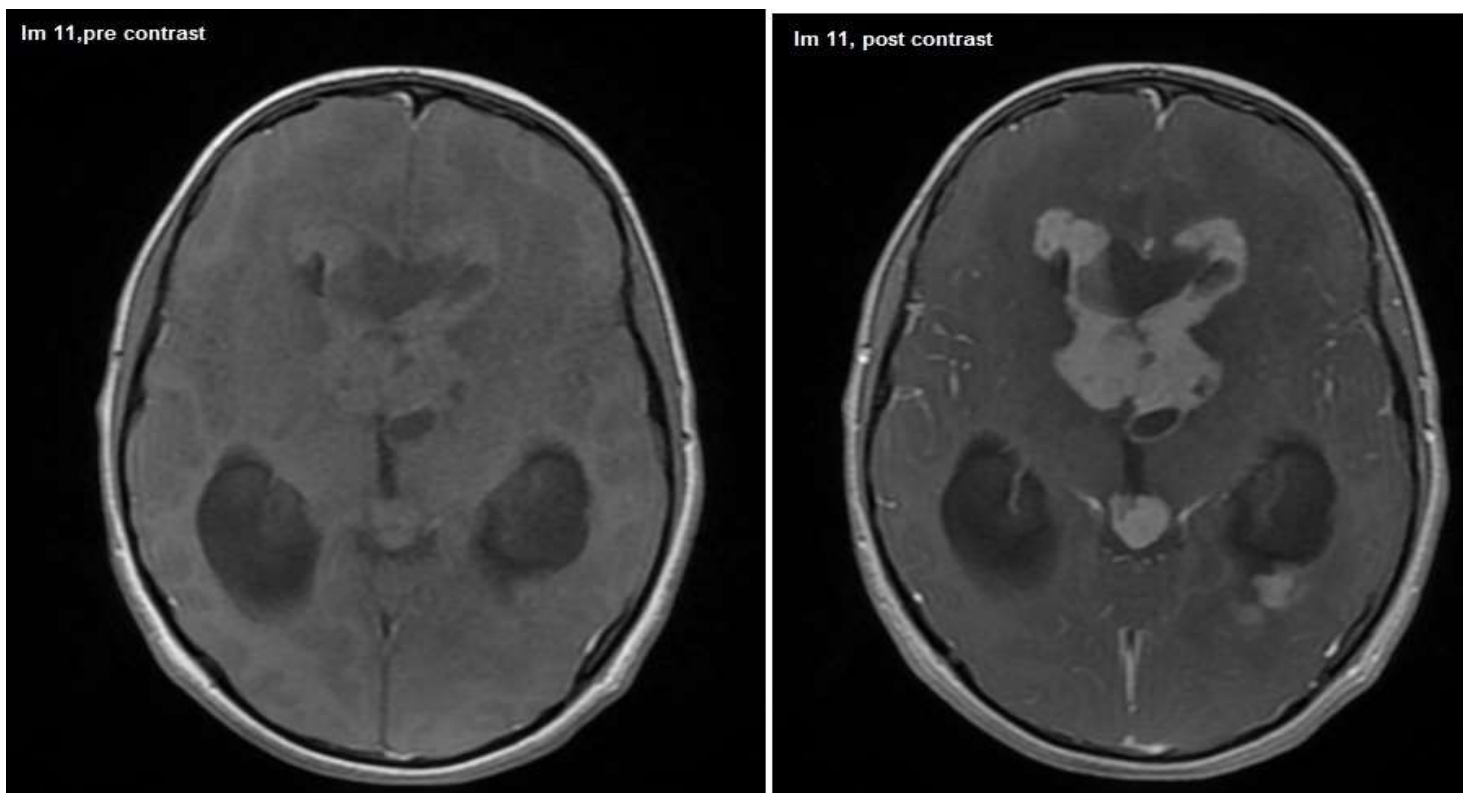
MRI image pre and post contrast- Enhancement with Necrotic
